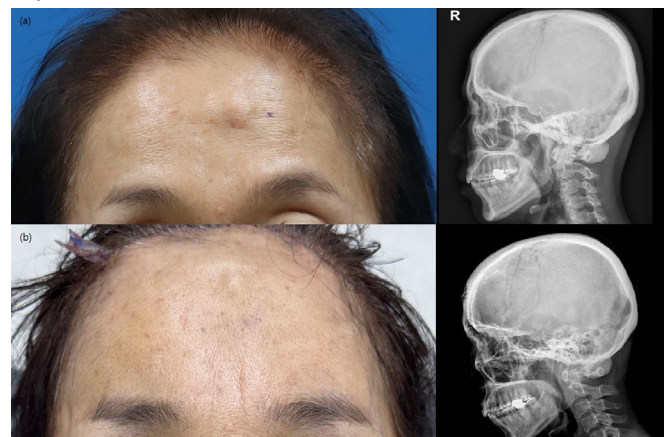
(a) Pre-surgical photograph and lateral skull radiograph of a 55-year-old female patient presenting with an osteoma on the left forehead within the STN region. (b) Post-surgical images and a lateral skull X-ray taken at three days demonstrate favorable wound healing concealed within the hairline, alongside a refined forehead profile.
